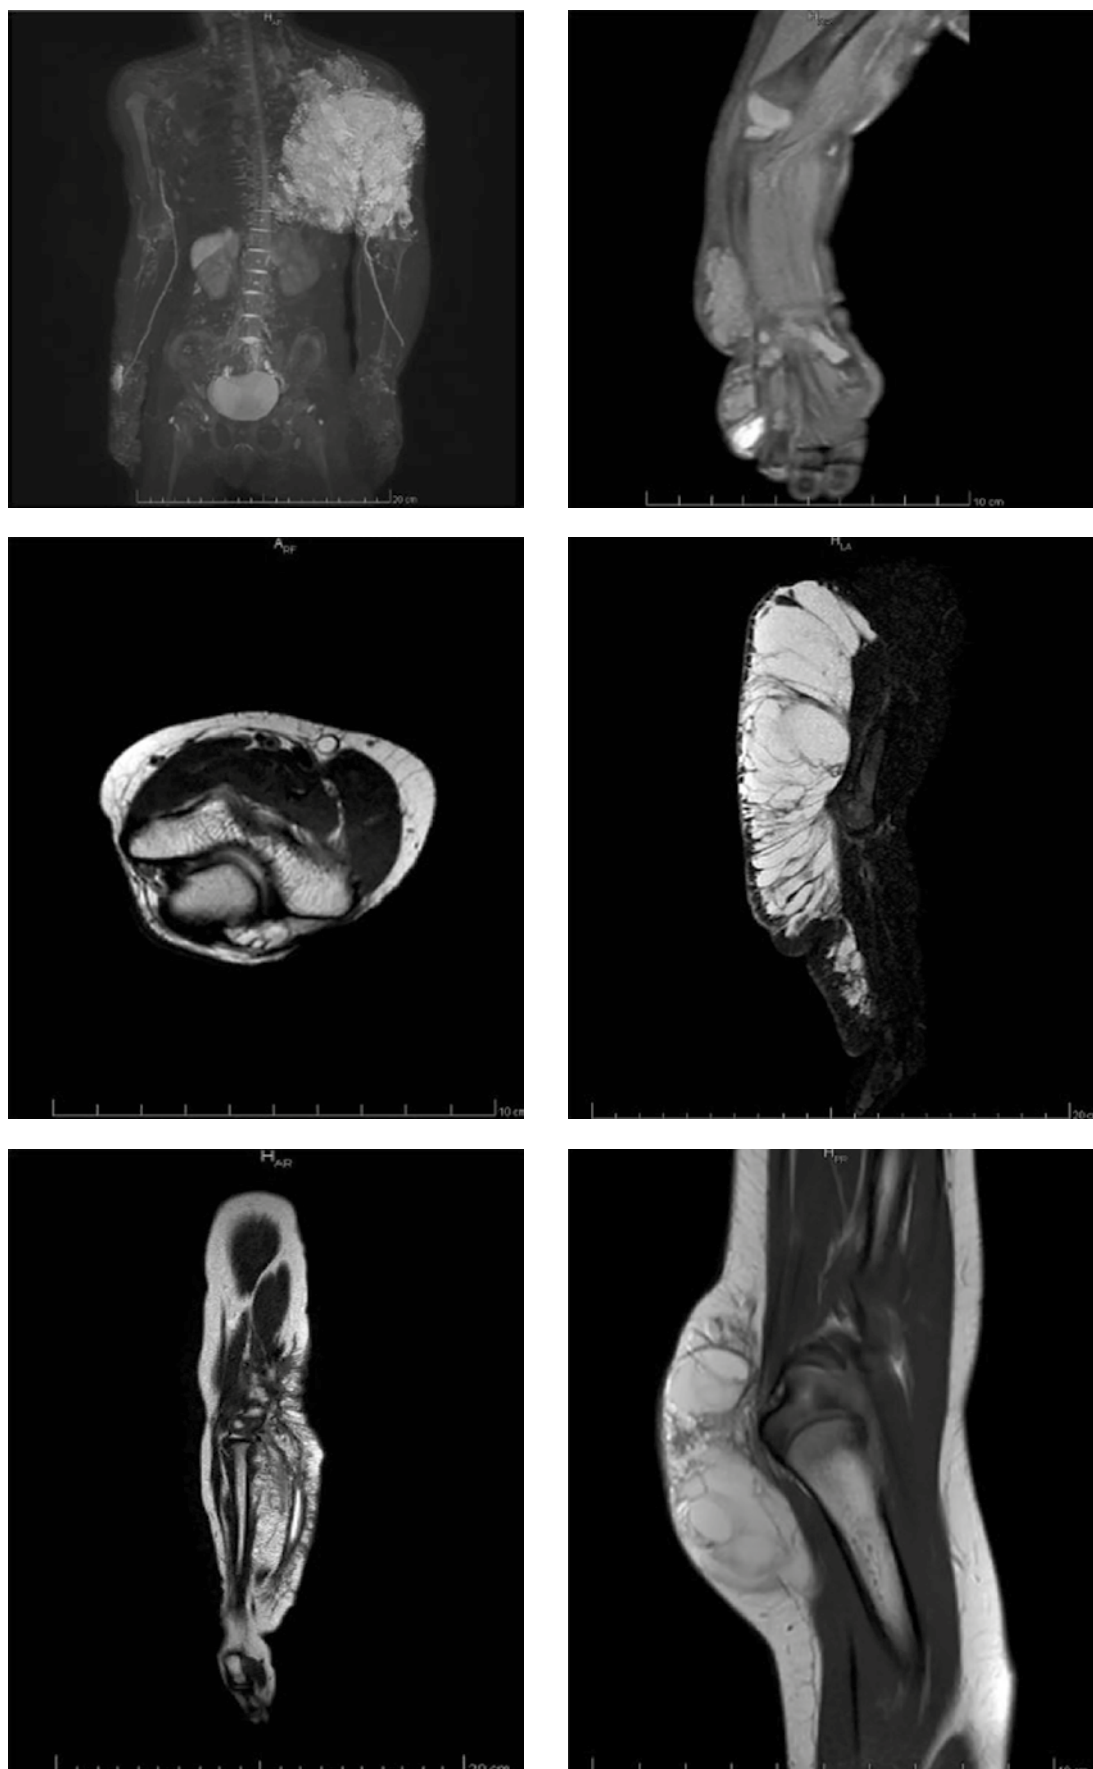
Radiological imaging of patients affected by lymphatic malformations of the upper extremity with ulnar distribution pattern (magnetic resonance imaging)
